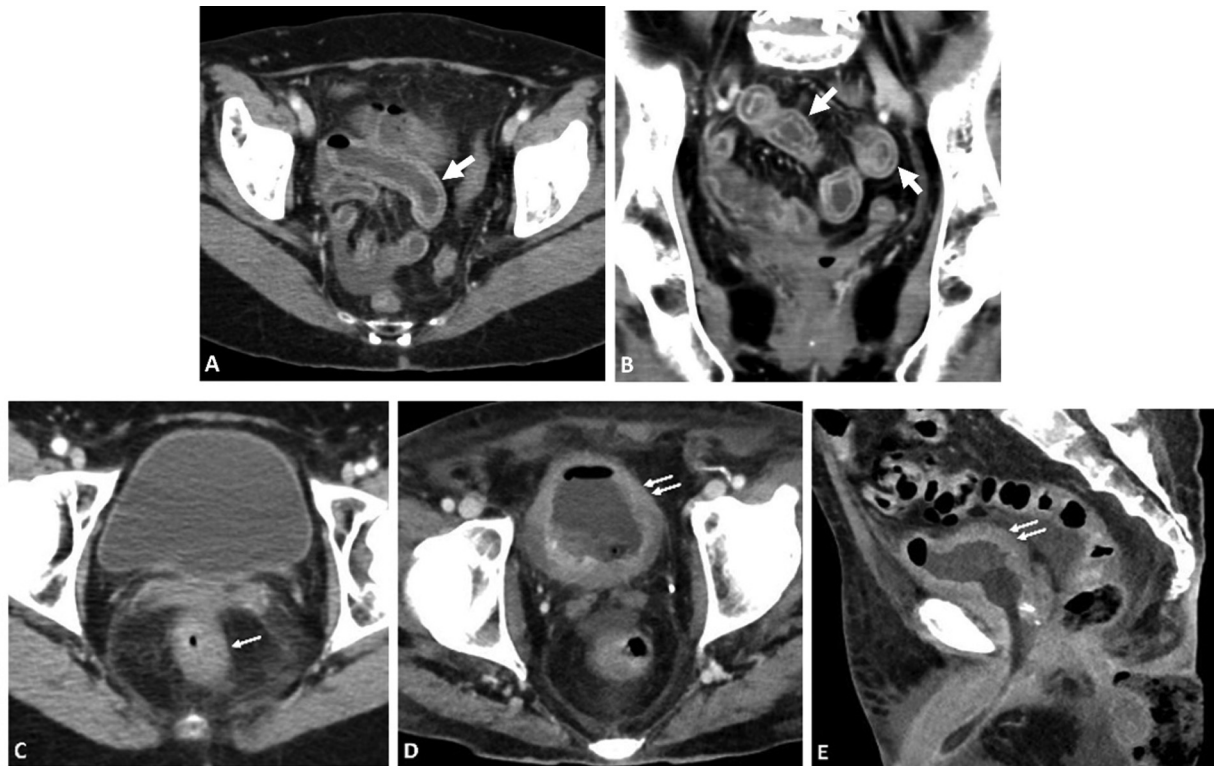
Post-radiation therapy (post-RT) complications. Contrast-enhanced computed tomography (CECT) in patients following external beam radiation therapy (EBRT) for prostate cancer showing a few complications. (A) Axial and (B) coronal reformatted images of radiation enteritis (*thick arrows*) with mural thickening and water halo sign involving the pelvic small bowel loops confined to the field of radiation. (C) Axial image of radiation proctitis (*thin arrow*) with rectal wall thickening and perirectal fat stranding. (D) Axial and (E) sagittal reformatted images of radiation cystitis (*double arrows*) with diffuse urinary bladder wall thickening.
